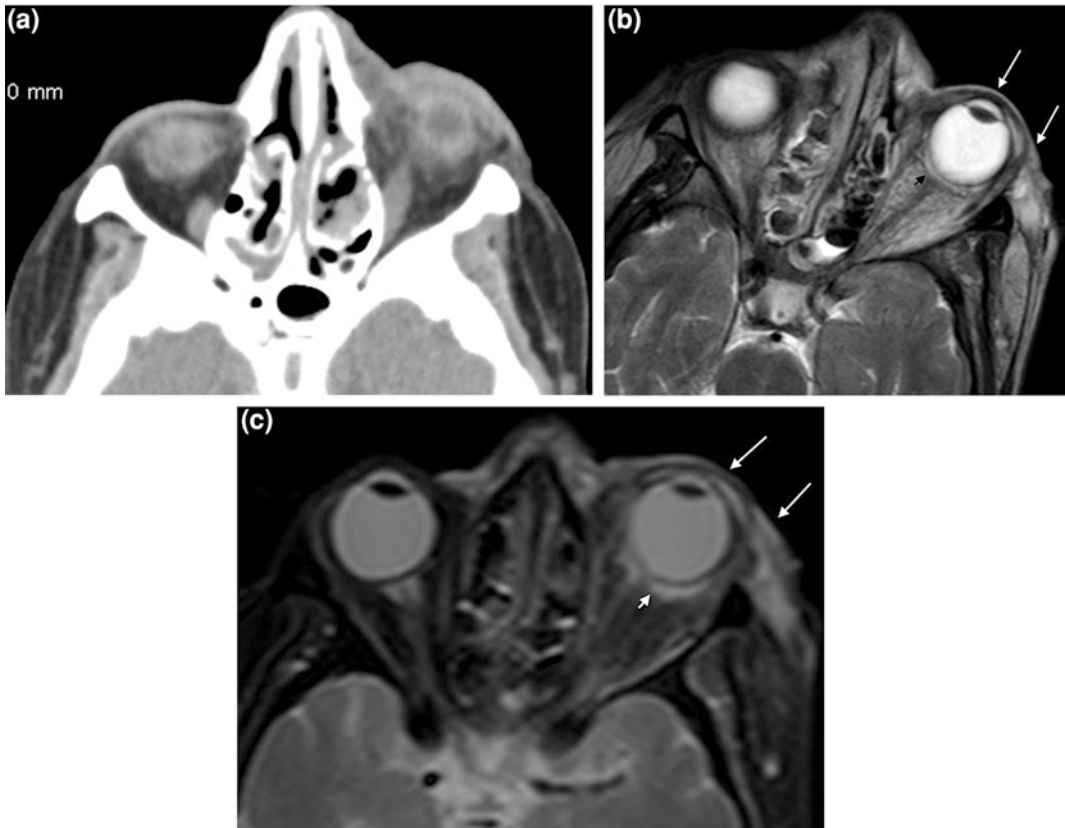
Periorbital and orbital cellulitis. a Axial non-contrast enhanced CT image demonstrates left periorbital soft-tissue edema, extending to the left cheek with proptosis of the left eye globe. b, c Axial T2WI, and T2WI with fat suppression images demonstrate edematous swollen preseptal tissue (arrows), together with retro-ocular orbital inflammation of high T2 signal (arrow head)
